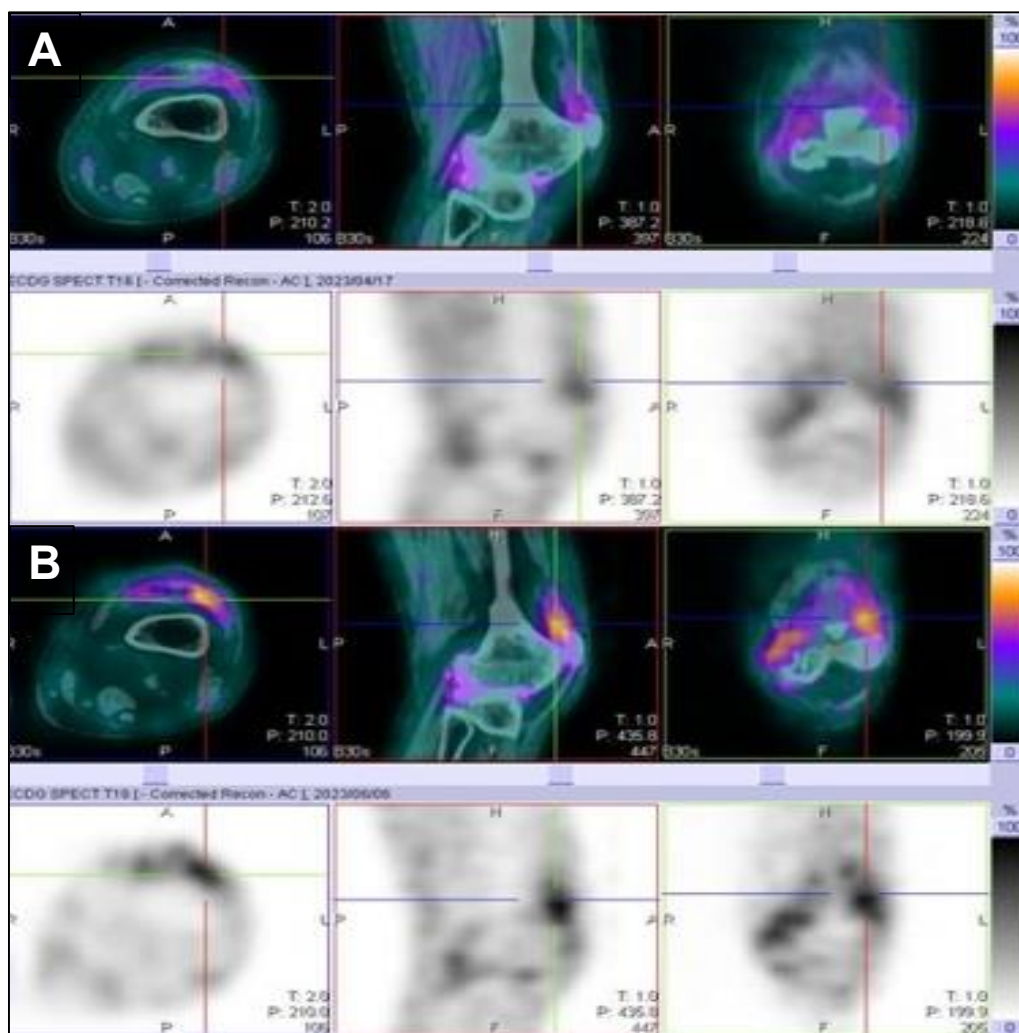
40-year-old female with worsened disease. SPECT/CT and SPECT images in the top row (A) show increased grade 2 uptake in the medial and lateral compartment of the left knee joint, in keeping with medial and lateral synovitis. SPECT/CT and SPECT images performed after 6 months (B) show worsening of disease with grade 3 uptake. Also note the persistent grade 1 uptake in the popliteal region in keeping with persistent low grade popliteal synovitis.
